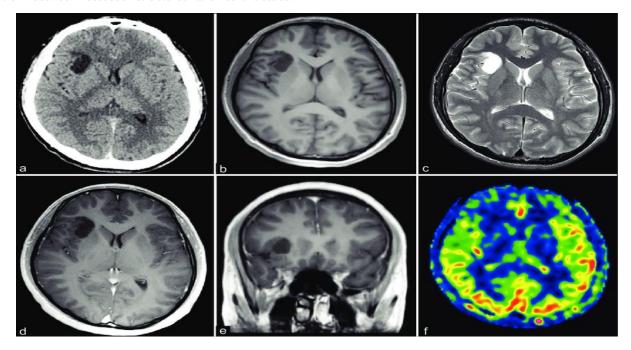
Axial computed tomography (CT) (a) and magnetic resonance imaging (MRI) scans
